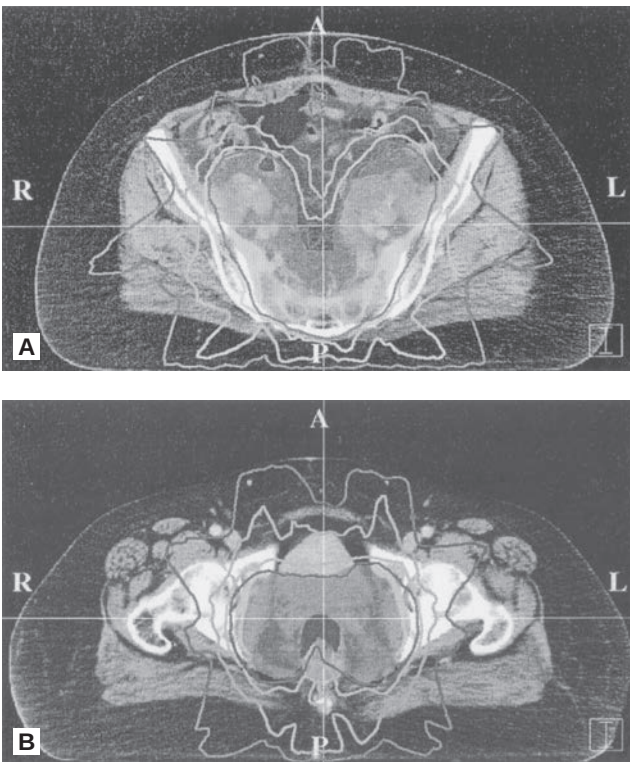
A: Isodose curves from a whole pelvic intensity-modulated radiation therapy plan superimposed on an axial CT slide through the upper pelvis. Highlighted are the 100%, 90%, 70%, and 50% isodose curves. B: Isodose curves from a whole pelvic intensity-modulated radiation therapy plan superimposed on an axial CT slide through the lower pelvis. Highlighted are the 100%, 90%, 70%, and 50% isodose curves.
